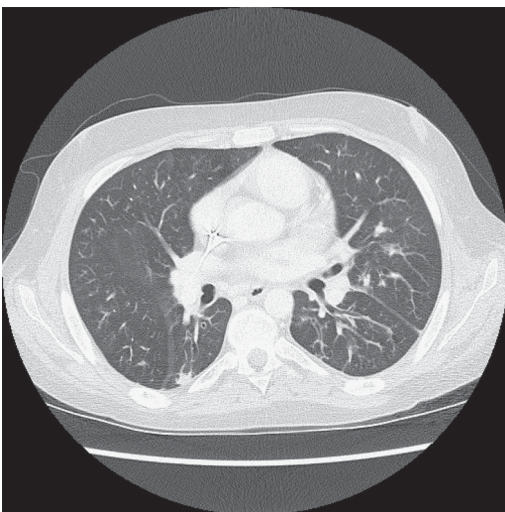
Chest CT scan demonstrating 2 dense nodules, one with a halo.
